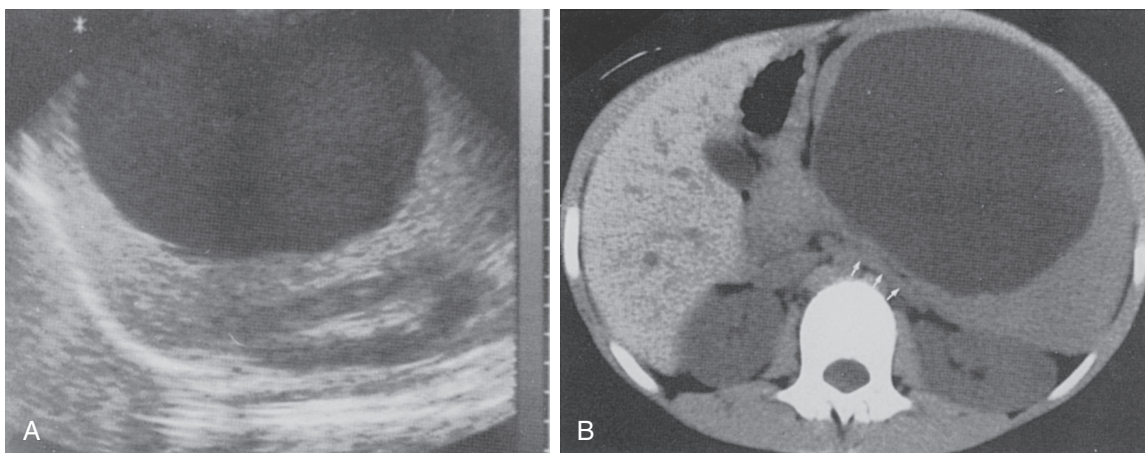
The large epidermoid cyst of the spleen in a boy, shown on ultrasonography (A), is shown by computed tomographic scan (B) to compress the left renal vein (arrows). The boy presented with varicocele.
